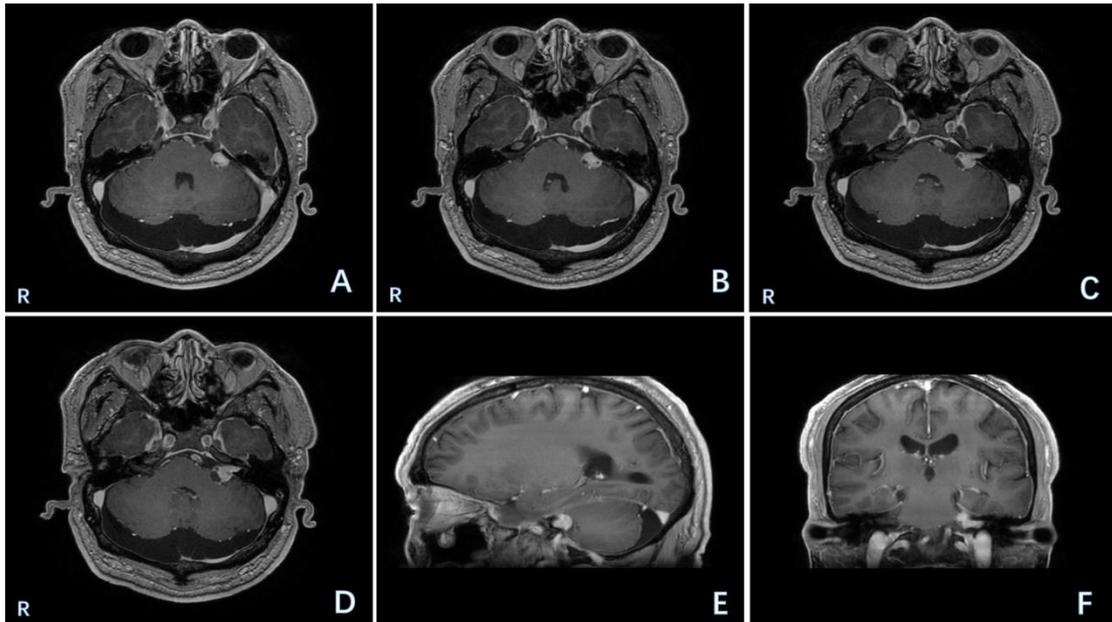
MRI showing a round mass with a size of 1.3 × 1.0 cm in the left CPA region. A-D: axial view, E: sagittal view, F: coronal view.
